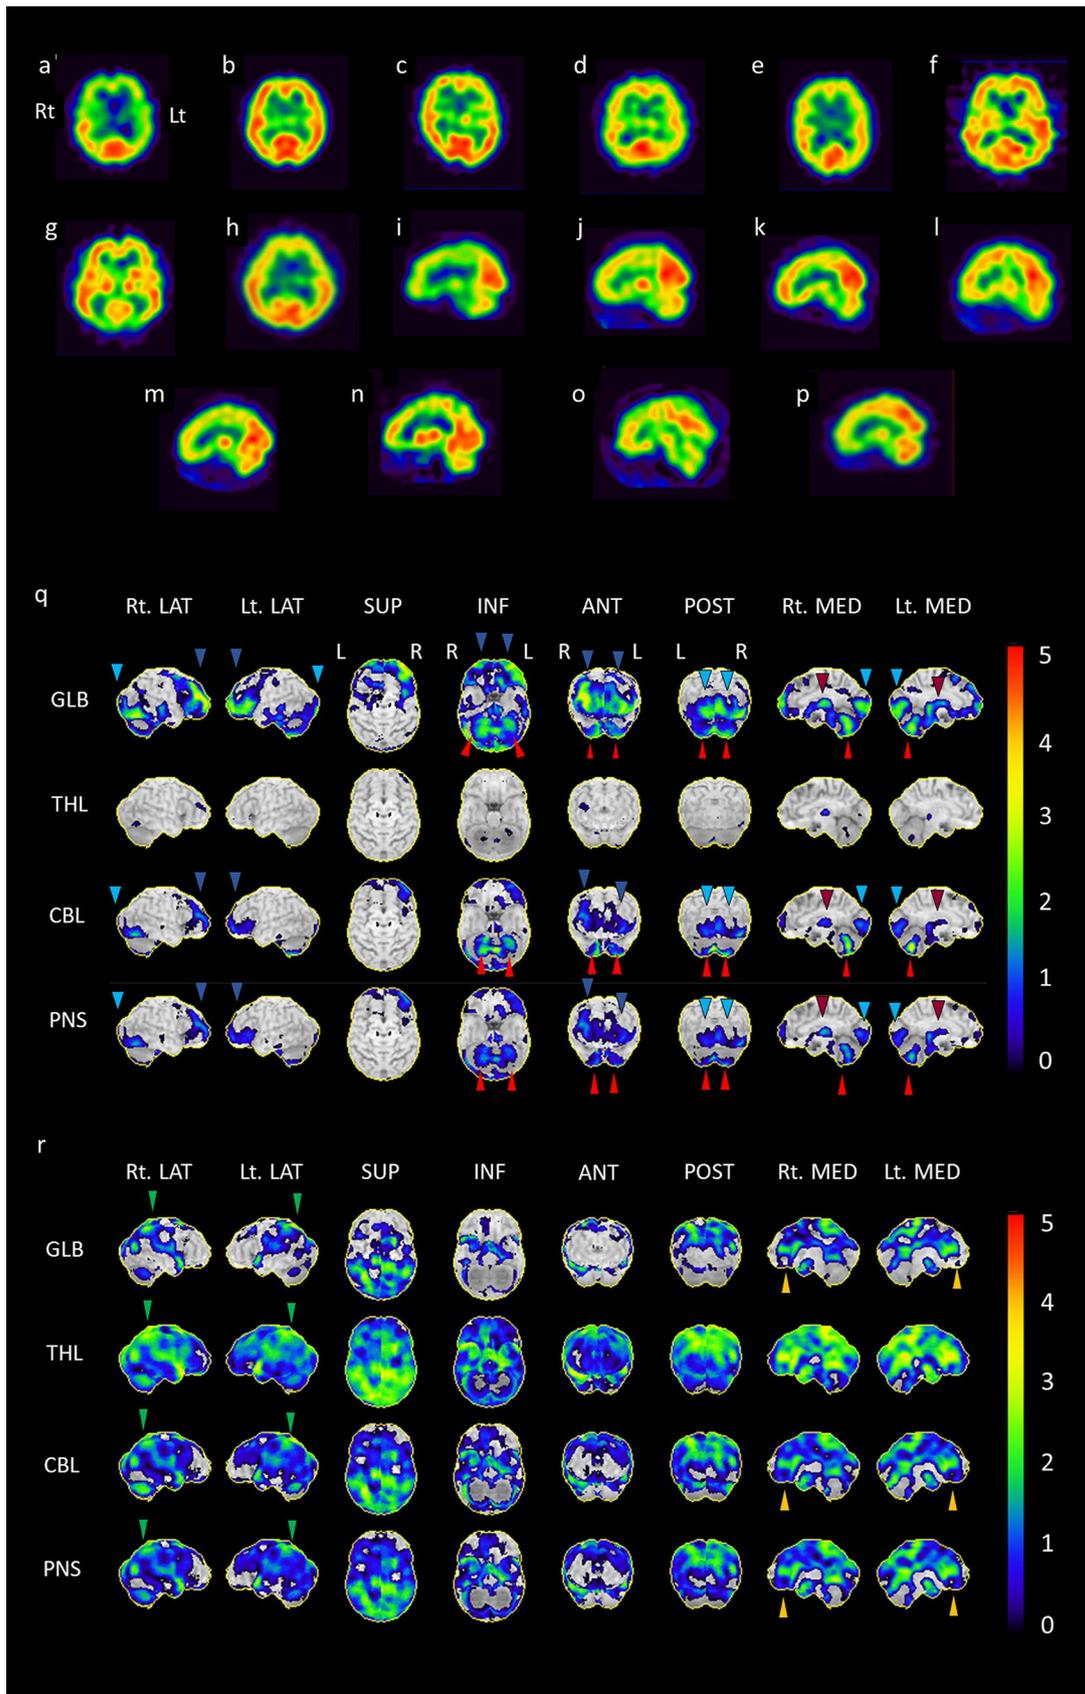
Brain single photon emission computed tomography imaging of seven patients with painful legs and moving toes syndrome. Brain single photon emission computed tomography (SPECT)-N-isopropyl-p-[¹²³I]-iodoamphetamine (IMP) images a–h show axial views at the level of lateral ventricles, and i–p show sagittal views at the level of the central position. The images (a, i) are for case 1 (b, j), depict case 2 (c, k), for case 3 (d, l), for case 4 (e, m), are for case 5 (f, n), for case 6, and (g, o) for case 7, and (h, p) for case 8. Images (a–h) indicate hypoperfusion in the bilateral frontal lobes. Images (i–o) indicate hypoperfusion in the frontal lobe and hyperperfusion in the parietal lobe. Images (g) and (o) indicate hypoperfusion localized in the bilateral occipital lobes. Image (o) depicts the three-dimensional stereotactic surface projection of SPECT-IMP, and a comparative study of the conjunctive analysis of our eight patients and 34 normal controls significantly revealed severe hypoperfusion on the surface of bilateral frontal lobes (dark blue triangle), occipital lobe (light blue triangle), and bilateral cerebellum (light red triangle), and thalamus (dark red triangle). Image (p) indicates remarkable hyperperfusion in the surface of bilateral primary and secondary somatosensory cortices (green triangle) and anterior cingulate gyrus (yellow triangle). *Rt* right, *Lt* left, *LAT* lateral, *SUP* superior, *INF* inferior, *ANT* anterior, *POST* posterior, *MED* medial, *GLB* global, *THL* thalamus, *CBL* cerebellum, and *PNS* pons
